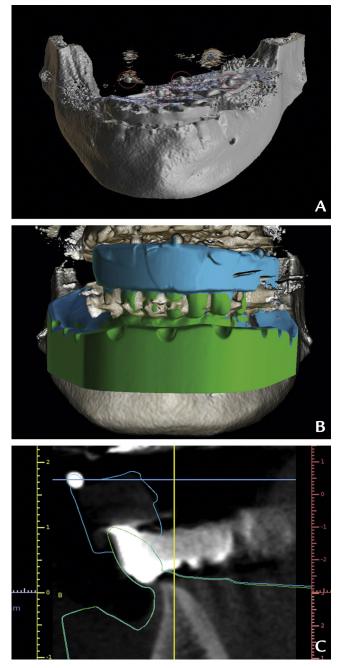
Diagnostic cast with device used to create scan to align with scan of diagnostic cast alone to computed tomography scan.
